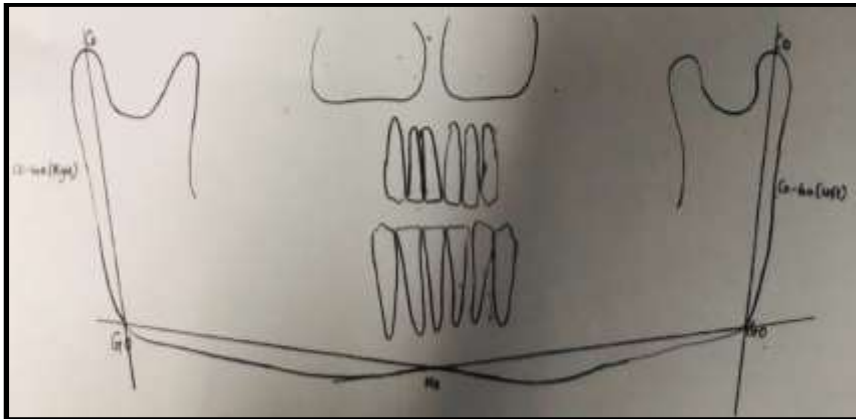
Orthopantomogram showing body length (Go-Me) and ramus height (Co-Go) on both sides. Landmarks depicted: Co-Condylion, Go-Gonion, Me-Menton
